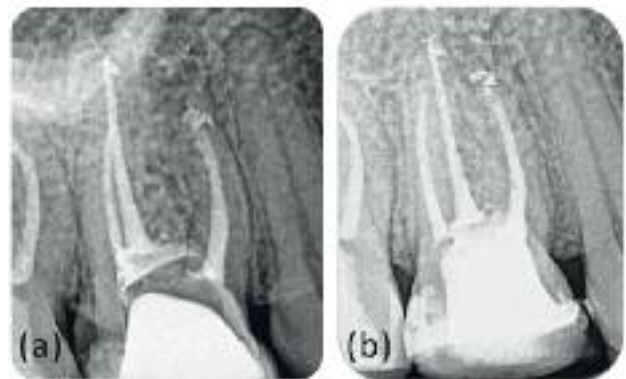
(a) Completed endodontic retreatment. (b) One-year follow-up radiograph.
